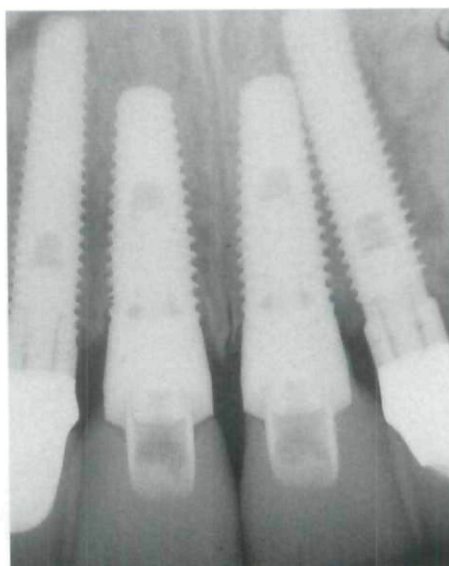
Radiographic image 1 year postoperatively. Interproximal bone peaks are evident between implants.
